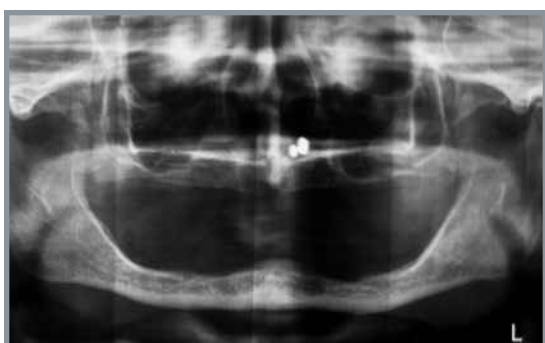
Panoramic radiograph demonstrating minimal amount of bone present in the maxilla and mandible for support of conventional dentures.
